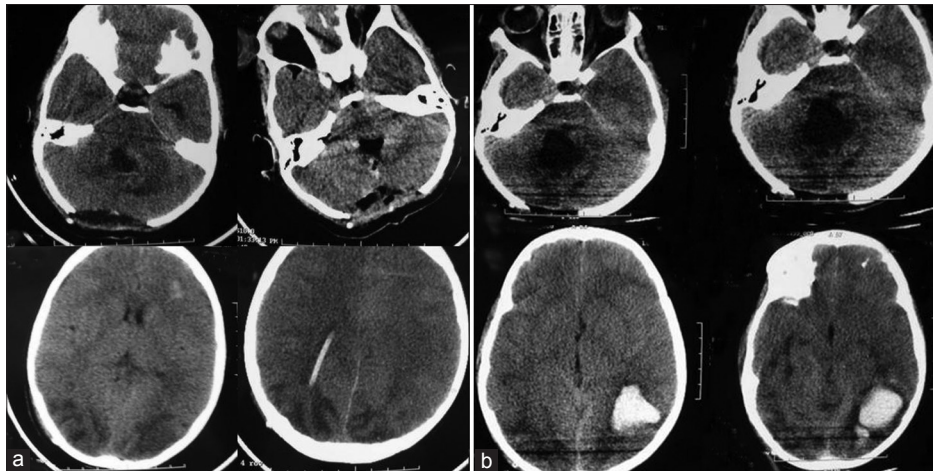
(a) Plain CT scan on postoperative day 1 showing total excision of tumor with no evidence of tumor bed hematoma. Bilateral occipital hypodensities are visualized suggestive of venous edema; (b) Plain CT scan on postoperative day 3 showing a left parietal hematoma
